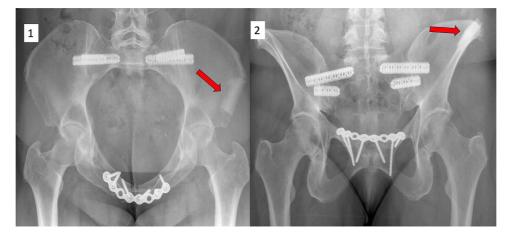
Radiographs of pelvis at 12 month follow up. 1. Inlet view; 2. outlet view; red arrows pointing at the iliac defect showing full integration of the b.Bone scaffold.
